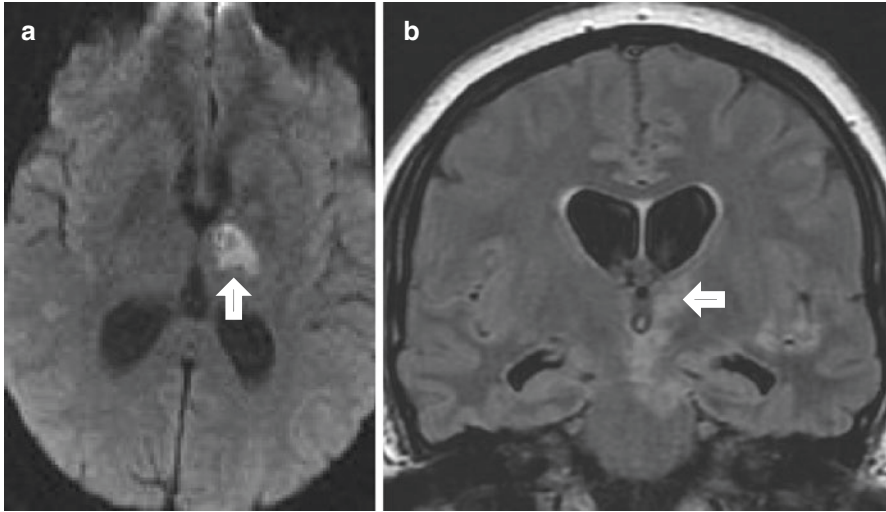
Infarct. In this patient with tuberculous meningitis, there is abnormal DWI (a) and FLAIR (b) signal in the left thalamus compatible with an infarct (arrows)
